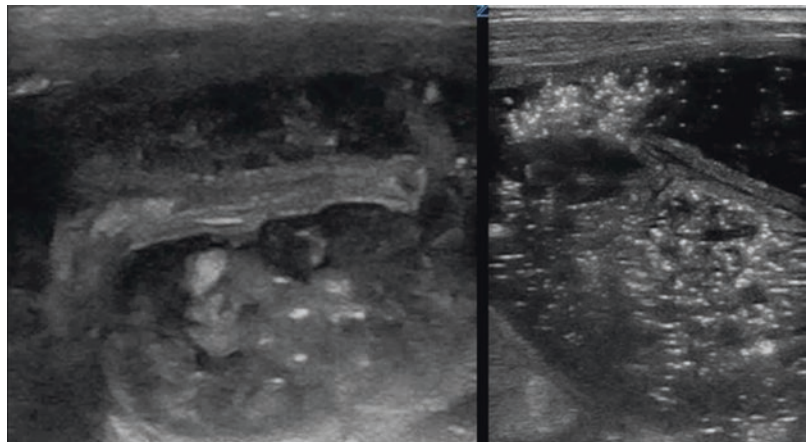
Midgut ultrasound image with donut-shaped loop and thin wall. This portion of the bowel was necrosed secondary to intrauterine volvulus in a newborn and surgically removed shortly after this ultrasound
